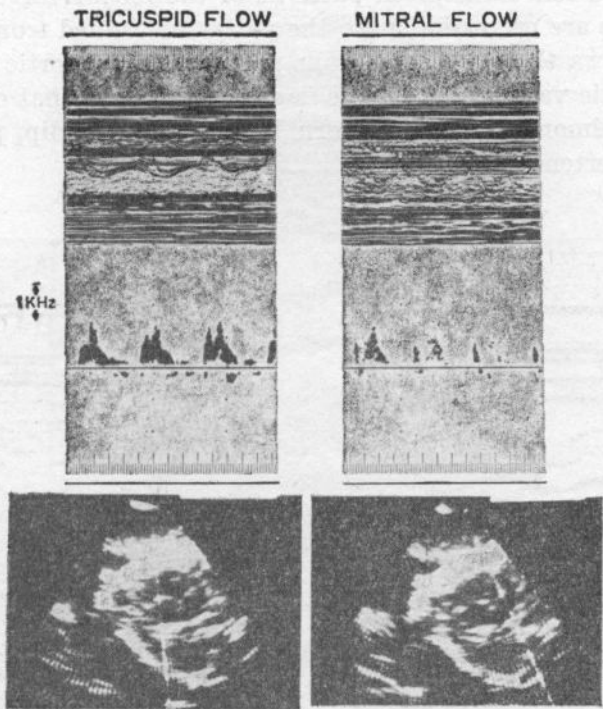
Doppler spectrum
